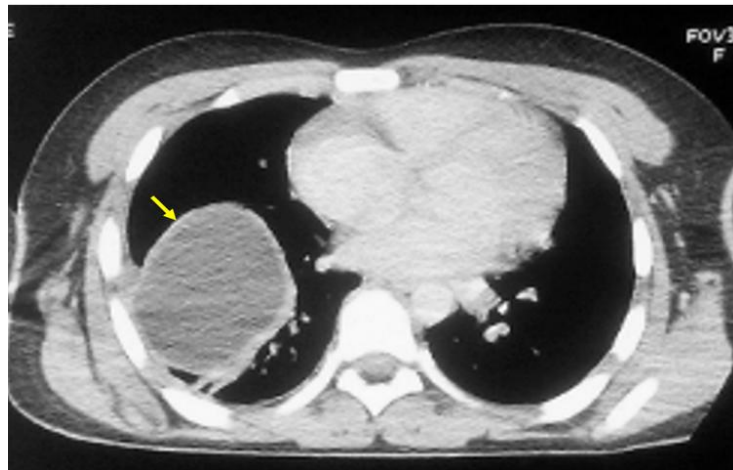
Thoracic CT (mediastinal window) of uncomplicated right PHC. Well-defined homogeneous fluid-density lesion (6 cm) in the right lower lobe (yellow arrow), consistent with an uncomplicated PHC. *CT, computed tomography; PHC, pulmonary hydatid cyst.*
